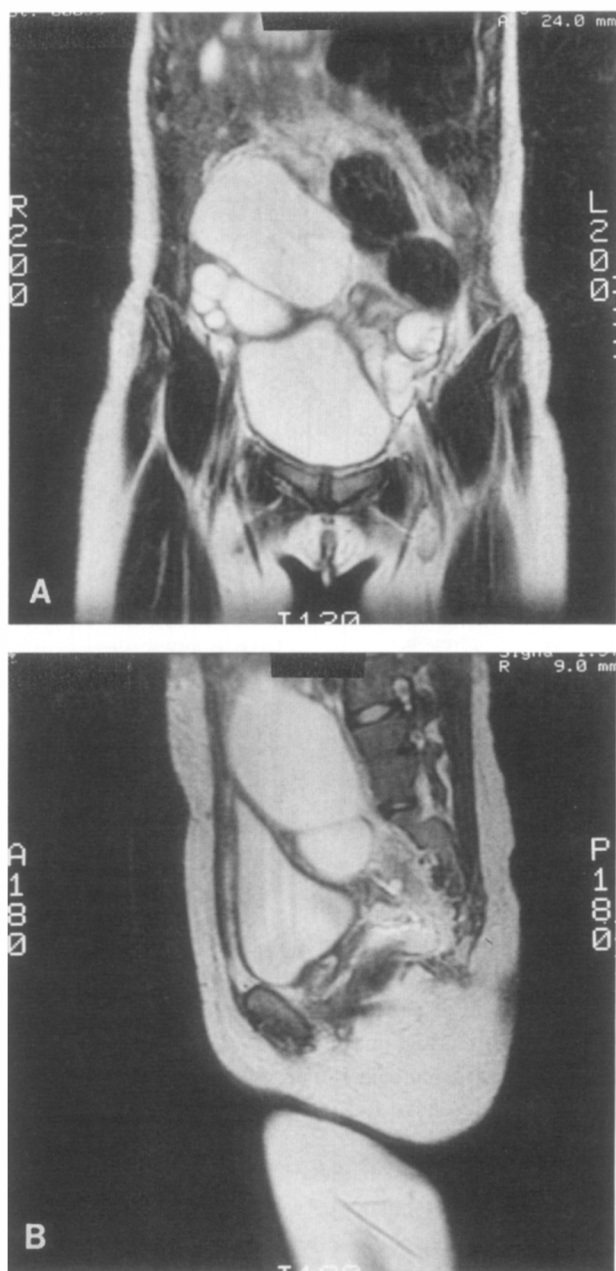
(A,B) Anterior-posterior and sagittal magnetic resonance images showing pelvic collections of menstrual blood.
